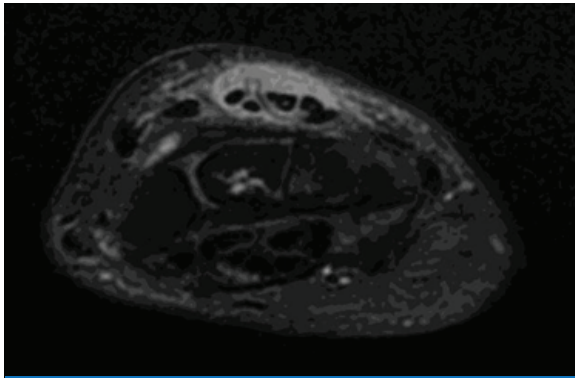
Axial, proton density fat sat image of the MRI of right wrist showing significant fluid within the sheath of Extensor digitorum communis, with synovial thickening and intra-substance hyperintensity.
